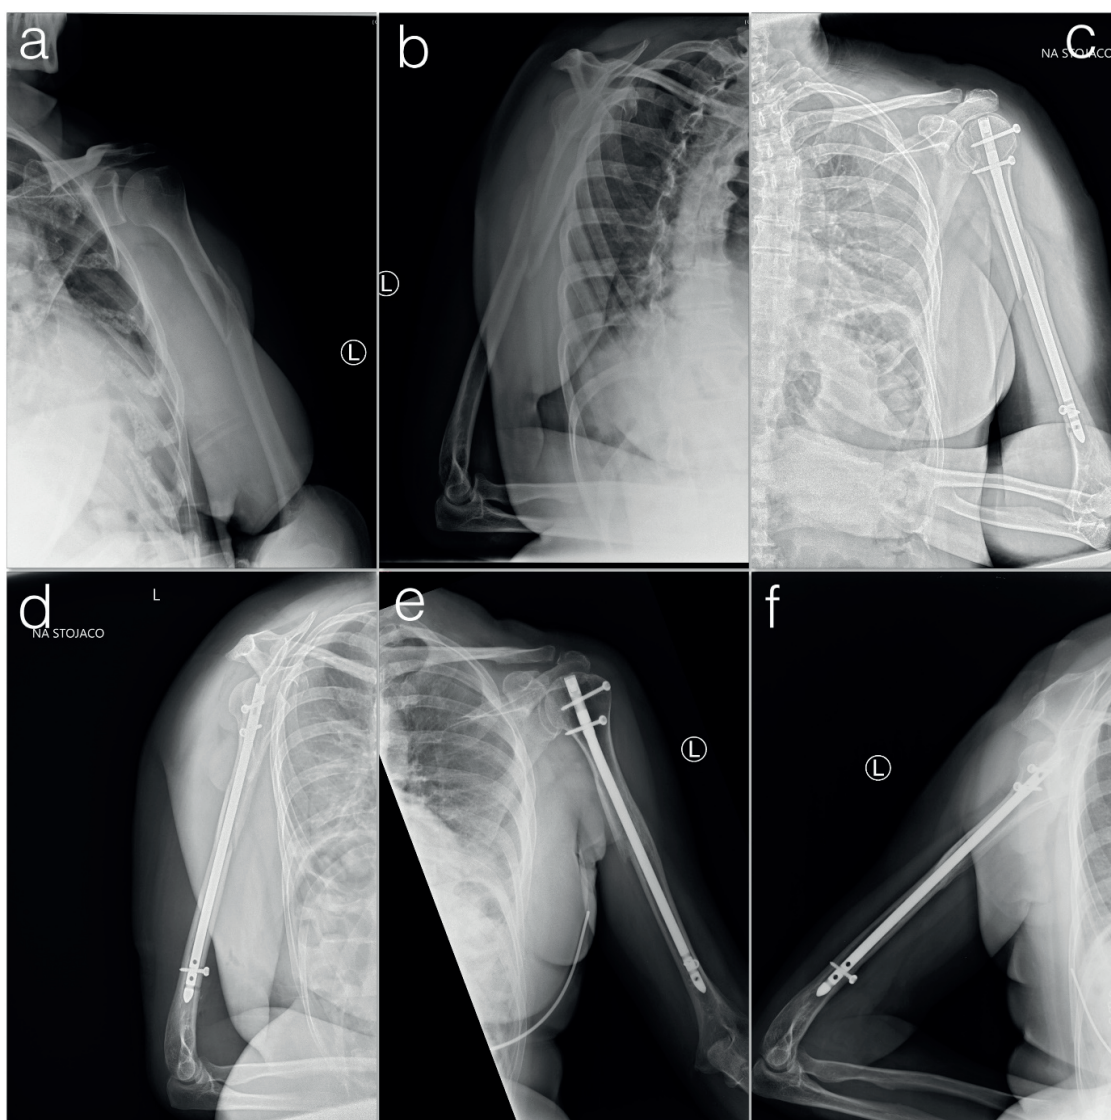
X-ray of middle 1/3 humerus fracture. Pre-operative (a, b), post-operative (c, d) and after 13 months from the surgery (d, e)
